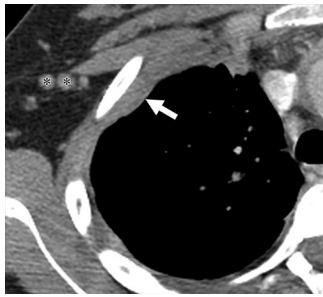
Lymphatic drainage of the upper costal pleura. Axial CT image shows axillary lymph nodes (*) and focal pleural thickening (arrow) secondary to pleural tuberculosis.
